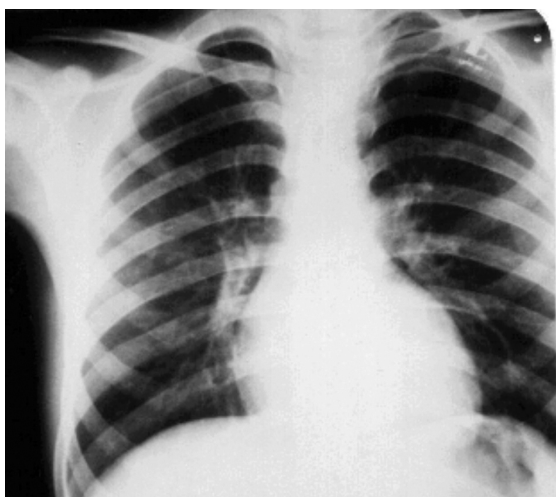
Chest x-ray taken two days later showing improvement of pulmonary edema.
